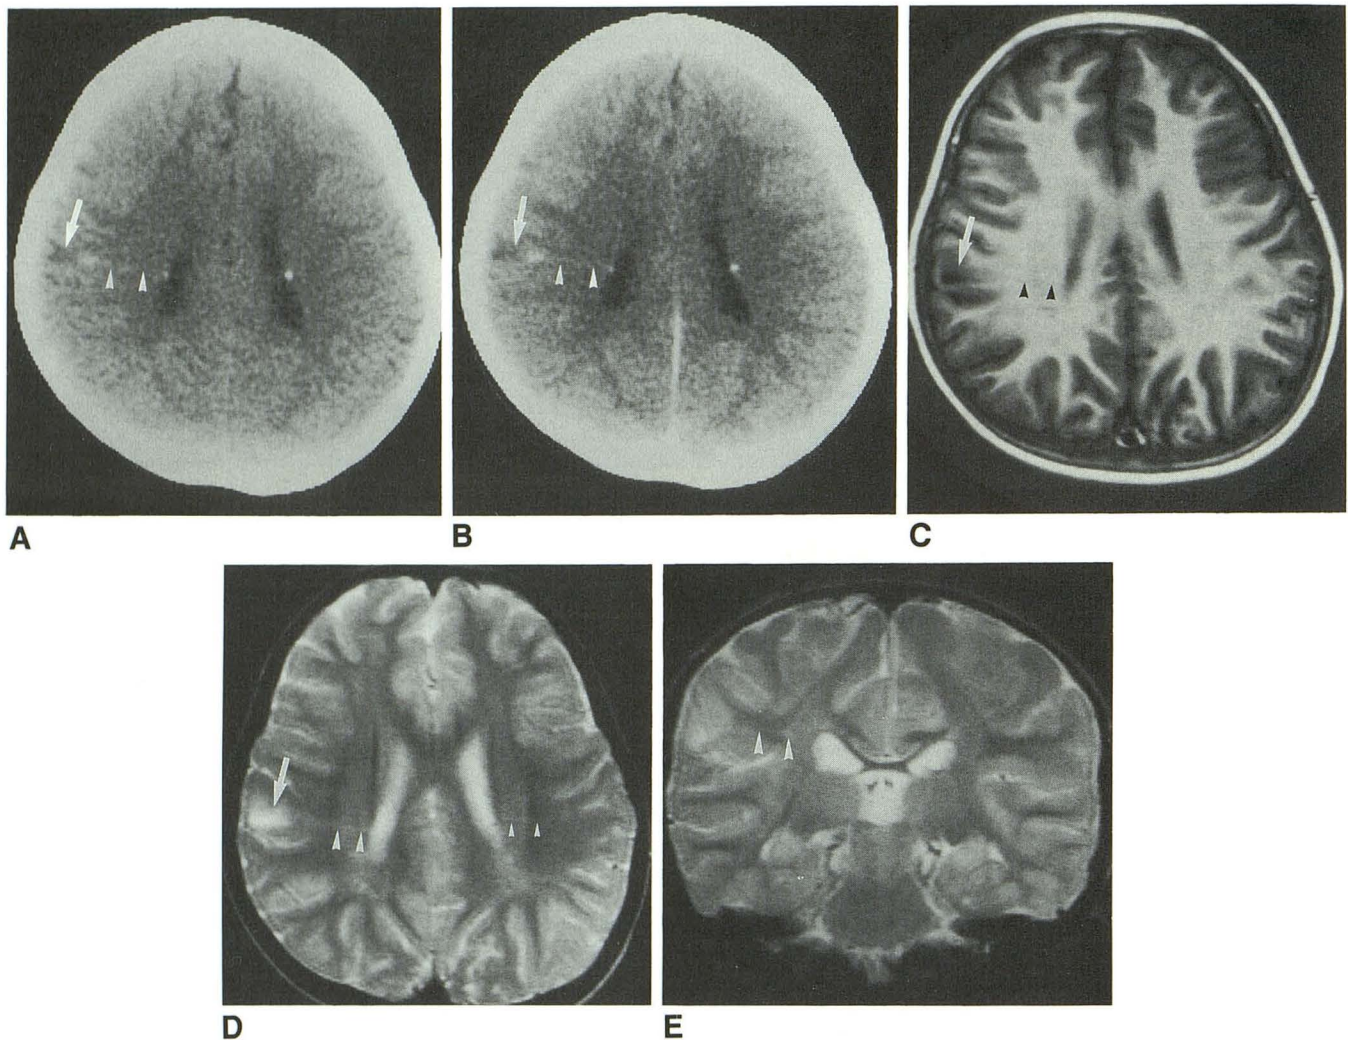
Case 2: 6-year-old girl. Plain (A) and enhanced (B) CT scans; T1-weighted MR image, IR 2500/30/600 (C); and transverse (D) and coronal (E) T2-weighted MR images, SE 2000/100 with MAST. A line (arrowheads) connecting subependymal nodule at right lateral ventricle to subcortical lesion (arrow) on supramarginal gyrus is seen as an area of faint high density on plain CT (A) without increase of density on contrast enhanced CT (B), as an area of hypointensity on T1-weighted MR image (C), and as an area of hyperintensity on T2-weighted MR images (D and E). A very faint hyperintense line (small arrowhead in D) appears to run from a small subependymal nodule in left lateral ventricle to the cortex, but evidence of subcortical lesion is not distinct.
